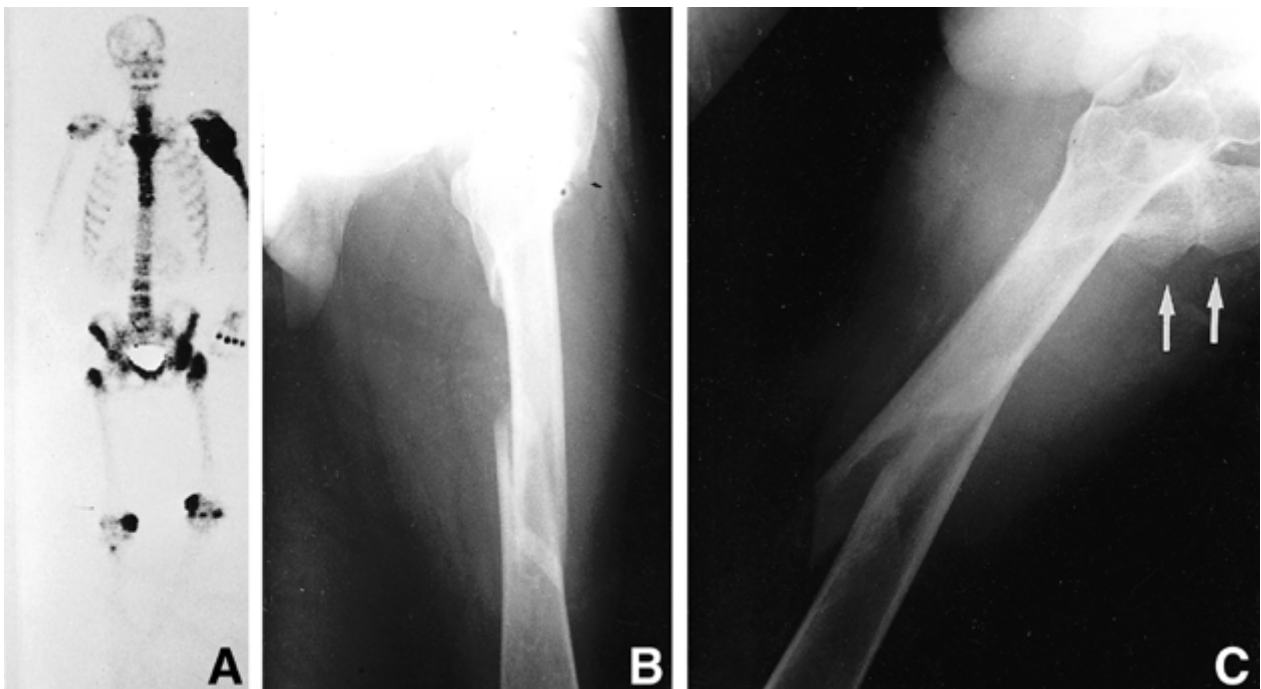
(A) Pre-fracture whole body bone scan finding of case 1 shows multiple hot uptakes in the left side of body including left hip. (B, C) Simple radiographic finding of case 1 shows spiral fracture occurred at the tip of heterotopic ossification (arrows) of the left femur which shows relatively thick cortex.
